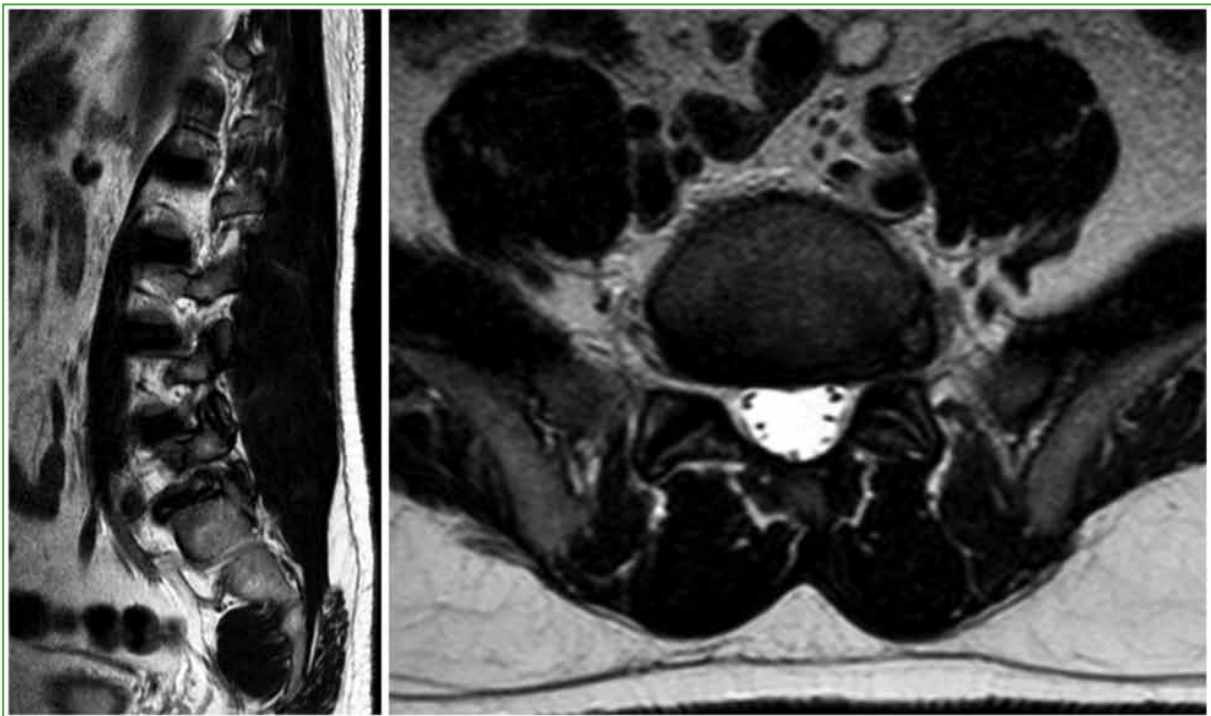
Magnetic resonance imaging of the lumbosacral spine, sagittal and axial sections. An extraforaminal hernia is observed in the L5-S1 space on the left side.
